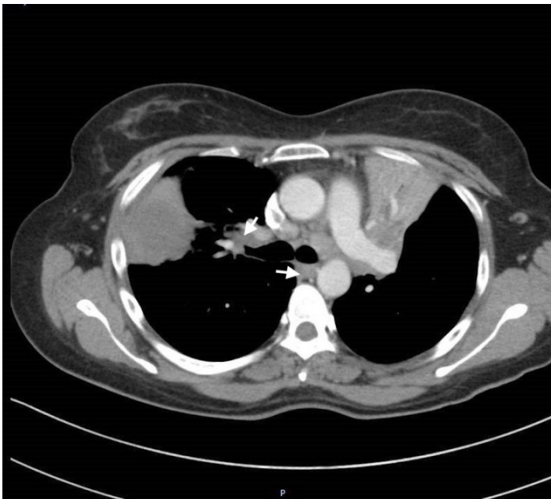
CT Thorax with mediastinal cuts showing enlarged mediastinal lymph nodes (white arrows).
